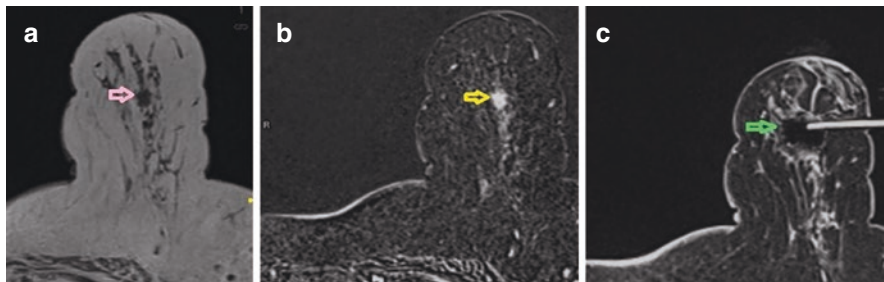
Non-contrast T2w axial image (a) shows a sub centimeter sized finely spiculated focal lesion (pink arrow) at the left peri areolar edge at 12 O clock position. Early contrast-enhanced T1-weighted fat sat image (b) depicts the corresponding mass in the left breast (yellow arrow). (c) Post biopsy cavity as seen on MRI guided vacuum assisted biopsy (green arrow). HPE: IDC
